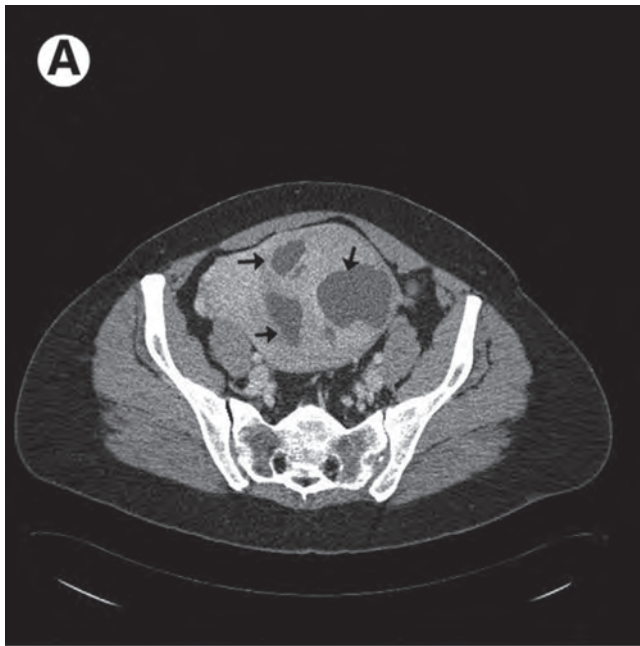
Cystic degeneration of fibroid. Axial CT image (A) and sagittal (B) T2-weighted MRI show cystic degenerating fibroids (arrow). (From Griffin Y, Sudigali V, Jacques A. Radiology of benign disorders of menstruation. *Semin Ultrasound CT MR*. 2010;31[5]:414–432.)
